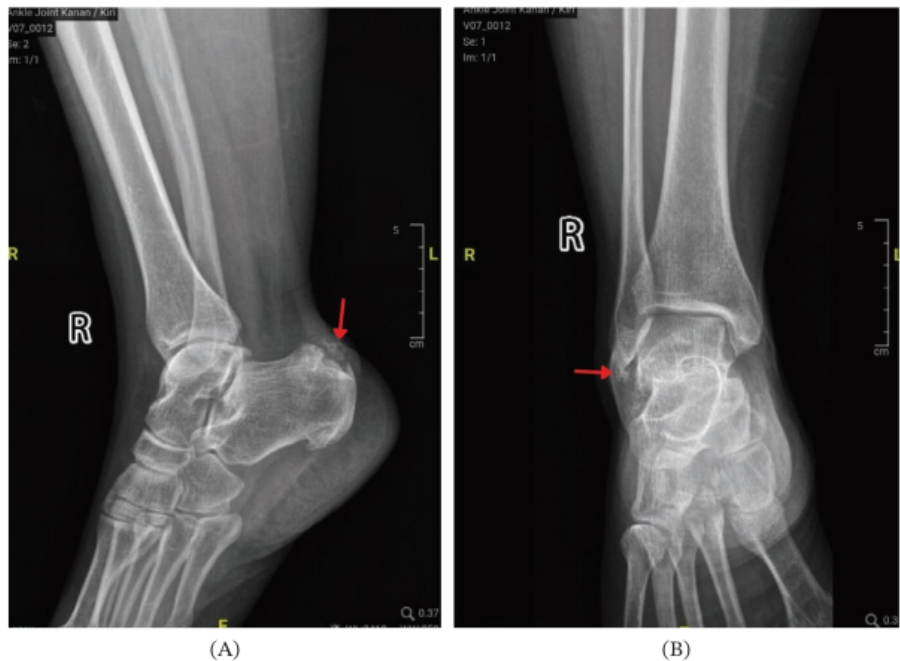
Plain radiographs of the right foot in (A) lateral and (B) anteroposterior views show a well-circumscribed soft tissue mass with internal calcification (red arrow).
